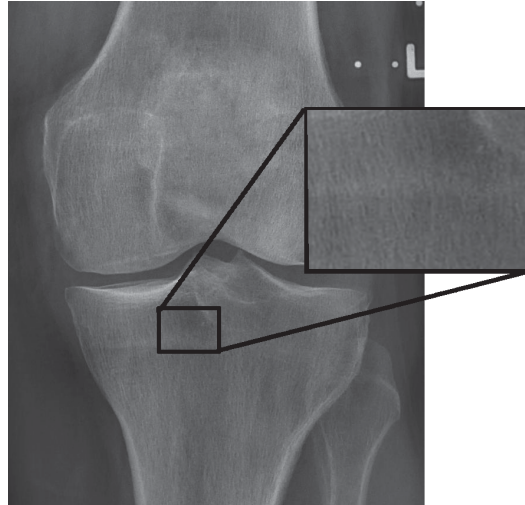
Trabecular bone structure seen in 2D projection radiographs
